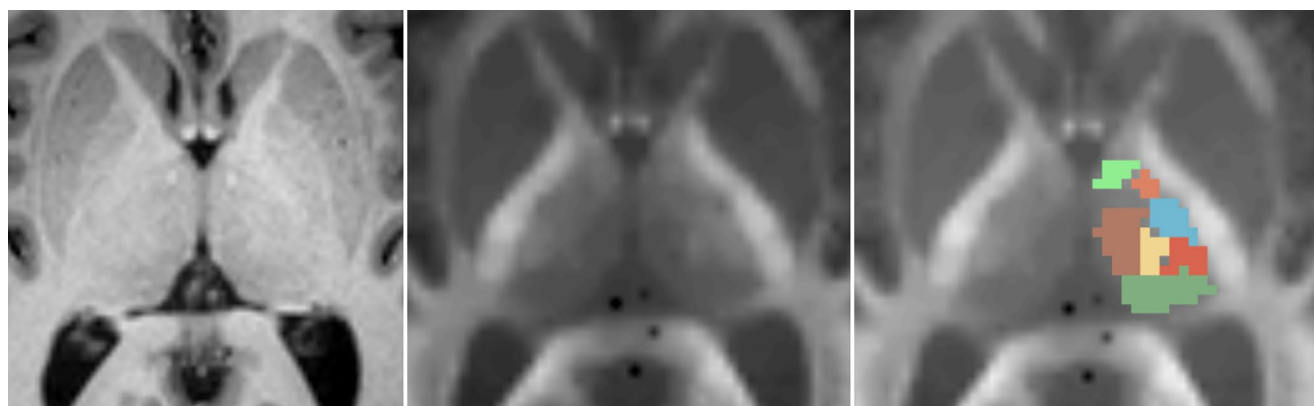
MRI-scan Qf the thalamic region. T1 MPRAGE, DWI at 5000 s/mm² without and with drawn in nuclei. (Green = pulvinar, light Brown = Nucleus medialis, Brown = Nuclei centrales, Blue = Nuclei ventrointermedii, Red = Nuclei ventrocaudales, Orange = Nuclei ventroorales and light Green = Nucleus lateropolaris thalami)
